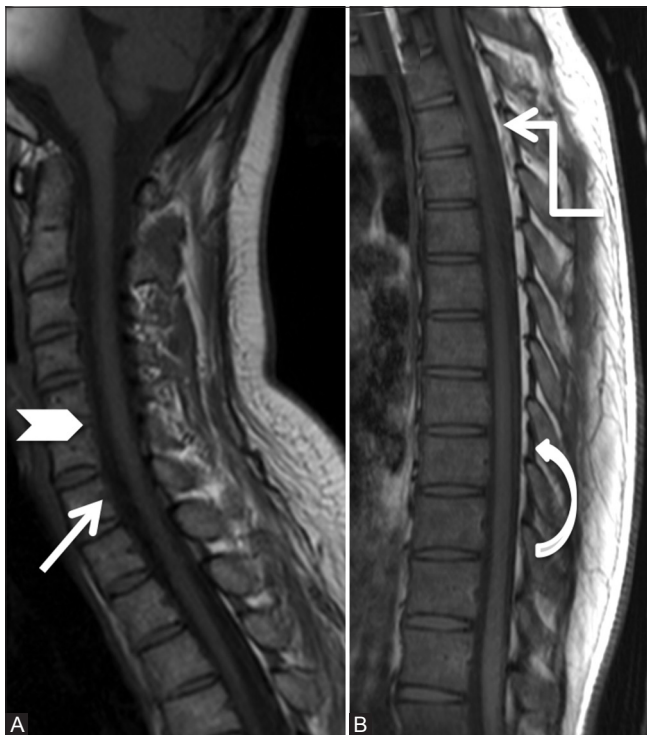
(A and B): Anatomy of epidural space: Sagittal T1-weighted images of cervical (A) and thoracic spine (B) showing posterior longitudinal ligament, posterior margin of vertebral bodies (arrow), and intervertebral discs (arrowhead) forming anterior margin of epidural space. The posterior margin is formed by ligamentum flavum (curved arrow), capsule of facet joints, and laminae. Note sheet-like posterior epidural fat in the dorsal spine (elbow arrow)
